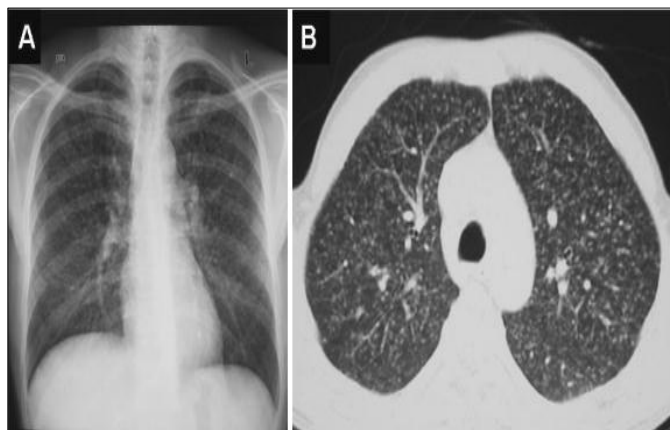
Chest radiograph (postero-anterior) (A) and chest CT (lung window) (B) showing classical miliary pattern.
